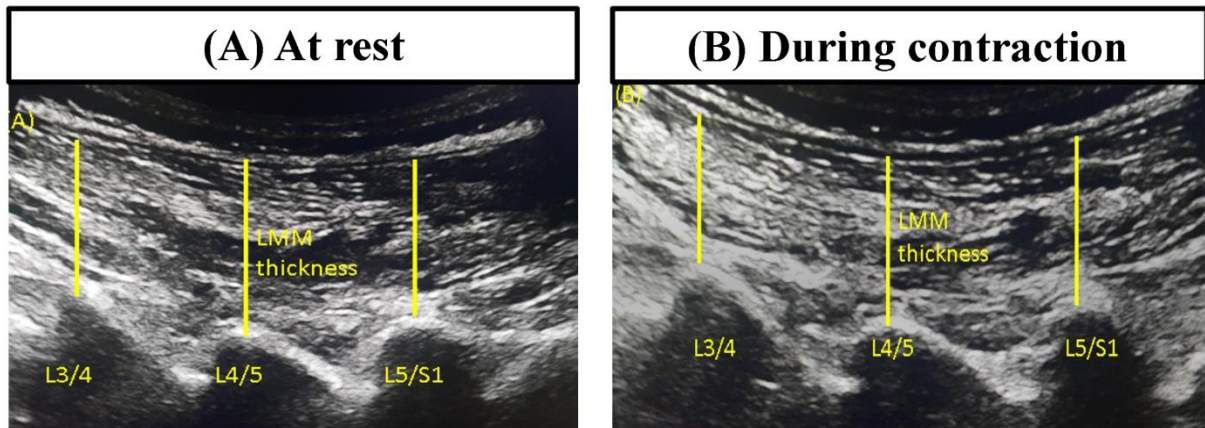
1 Thickness measurements of lumbar multifidus muscles using bright-mode ultrasound images (A) at rest and (B) during contraction.
